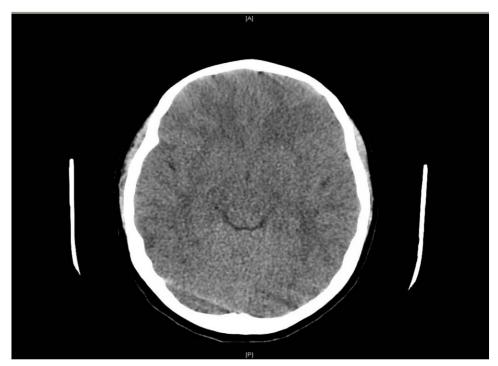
Brain CT of Patient F demonstrating mild cerebral edema.
